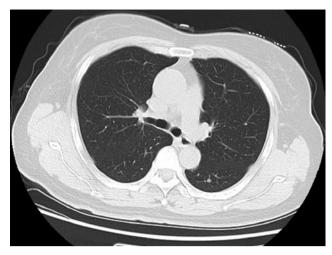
Chest computed tomography (CT) showing a number of tubercles in the right lung.
